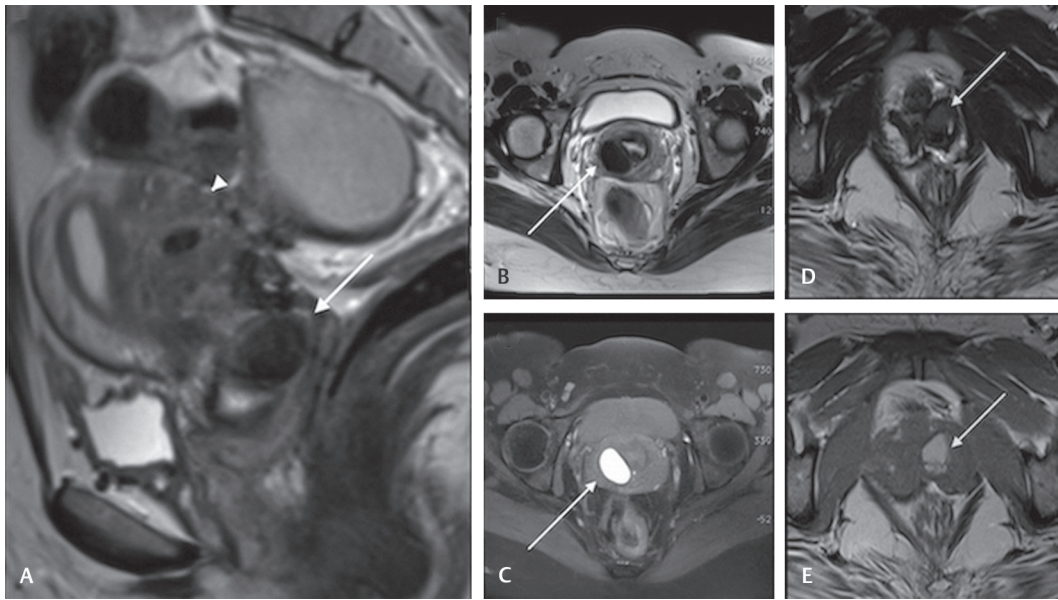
(A–E) T2W sag image (A) showing a cystic deposit in the posterior cervical lip and extending into the posterior fornix (*arrow*). T2W axial (B–D), T1W FS axial (C–E), showing similar deposits in the cervix (*arrows* in B and C) and vagina (D and E). Note is also made of a large deep endometriotic deposit in the posterior uterine myometrium (*arrowhead*). T2W, T2-weighted.
